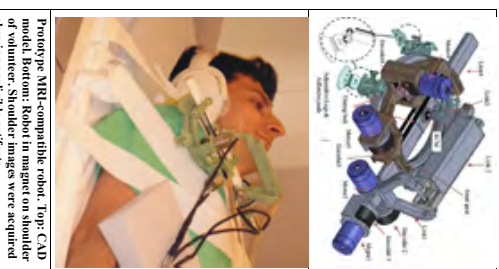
Prototype MRI-compatible robot. Top: CAD model. Bottom: Robot in image on shoulder of volunteer. Shoulder images were acquired showing negligible artifacts.
